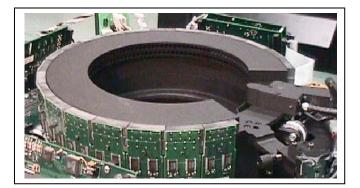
Laser scanning electronics. Detectors are arrayed around the breast in a CT-like design.
